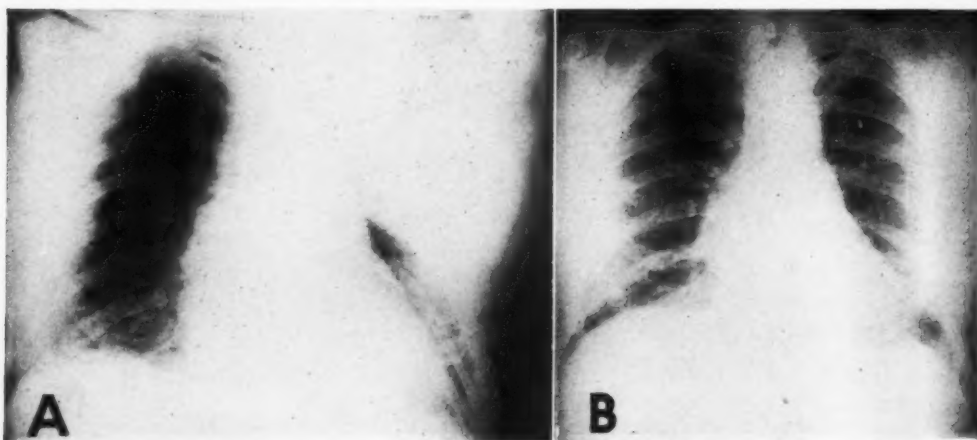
Case 7: A. Mycotic lesions in right base; traumatic pneumonia in left lung. B. Roentgenogram made two months later, showing resolution of pneumonia; the lesions in the right base persist but are improved.
